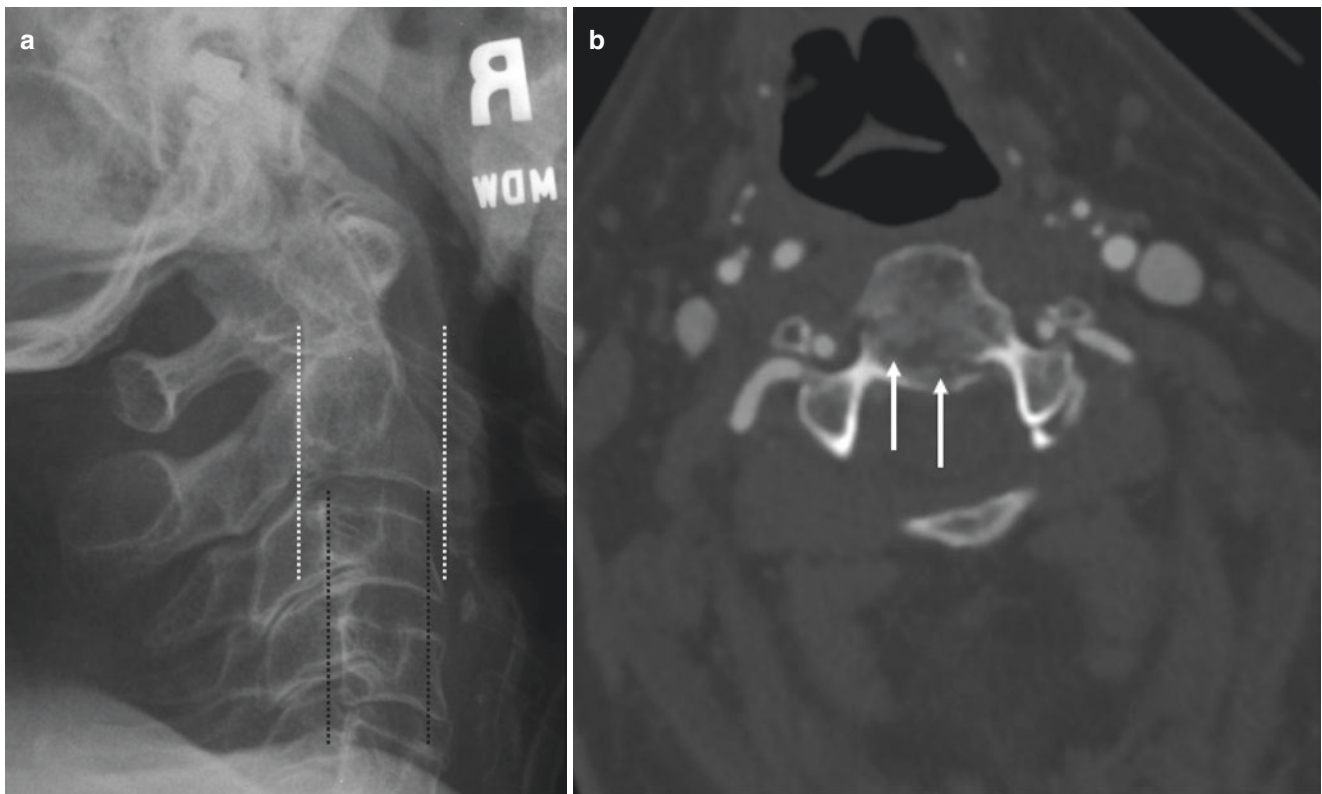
A 79-year-old woman who was T-boned in a motor vehicle accident. (a) Lateral radiograph of the cervical spine demonstrates wider anterior-posterior (AP) diameter of the C2 vertebral body (white
